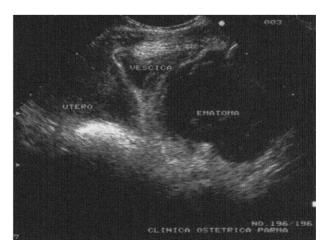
The pelvic mass still present at the follow-up transabdominal ultrasound examination (Utero: uterus; vescica: bladder; ematoma: haematoma)
